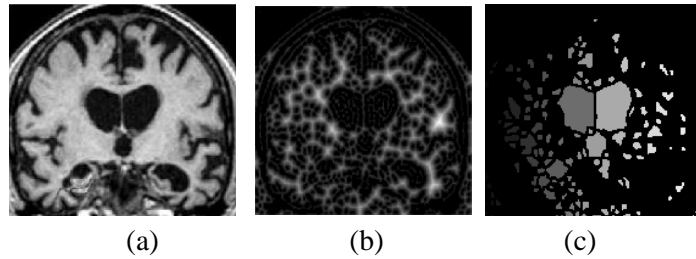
Atrophied Brain MRI: (a) Original (b) Segmented Image (c) Segmented Area
